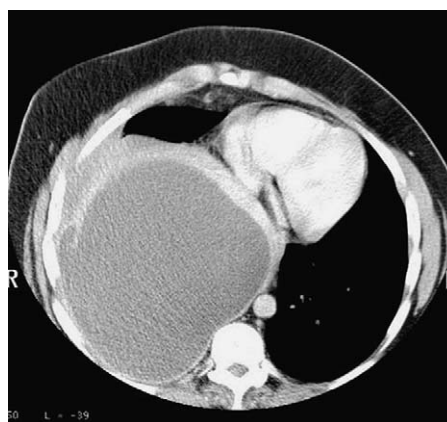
CT scan of empyema.
